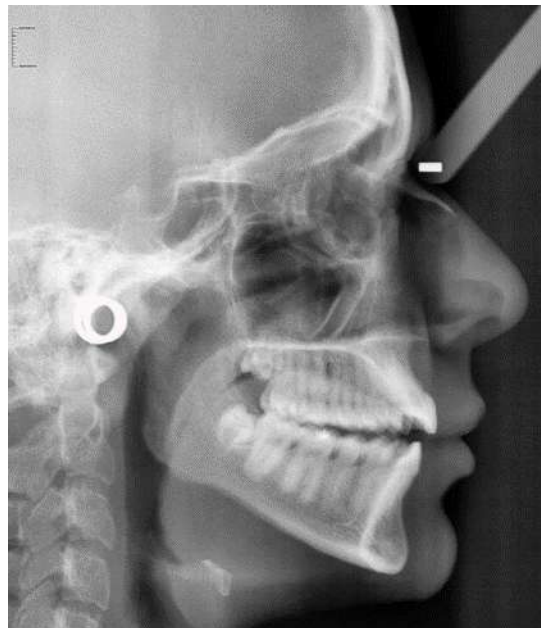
showing Lateral Cephalometric radiograph.
